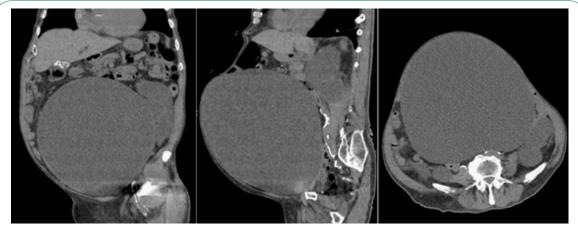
CT images in coronal, sagittal, and axial sections.
